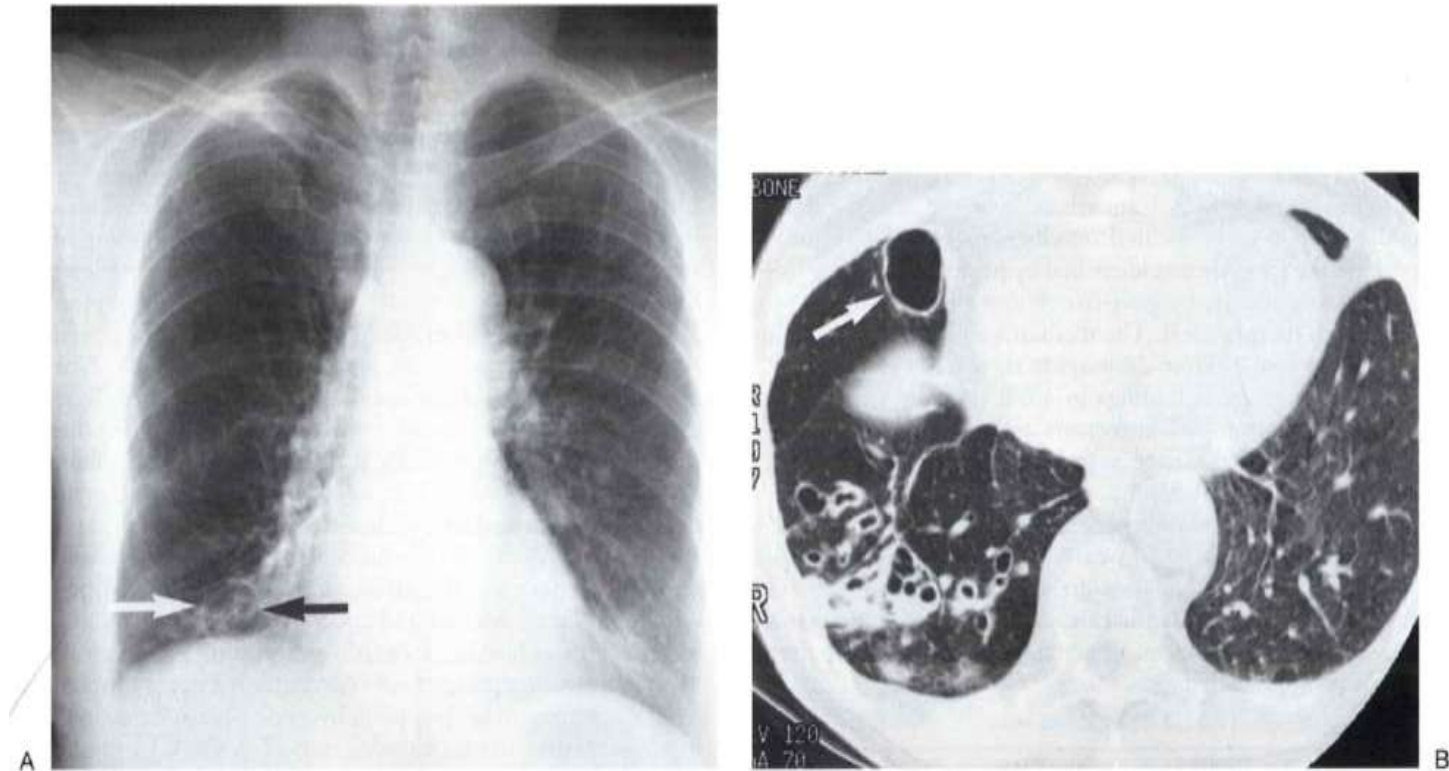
Cystic bronchiectasis. CT of a 65-year-old woman with a history of *Pasteurella multocida* infection of the lungs shows dilated bronchi and bronchioles, forming a “cluster of grapes” in the right lower lobe (arrows).
